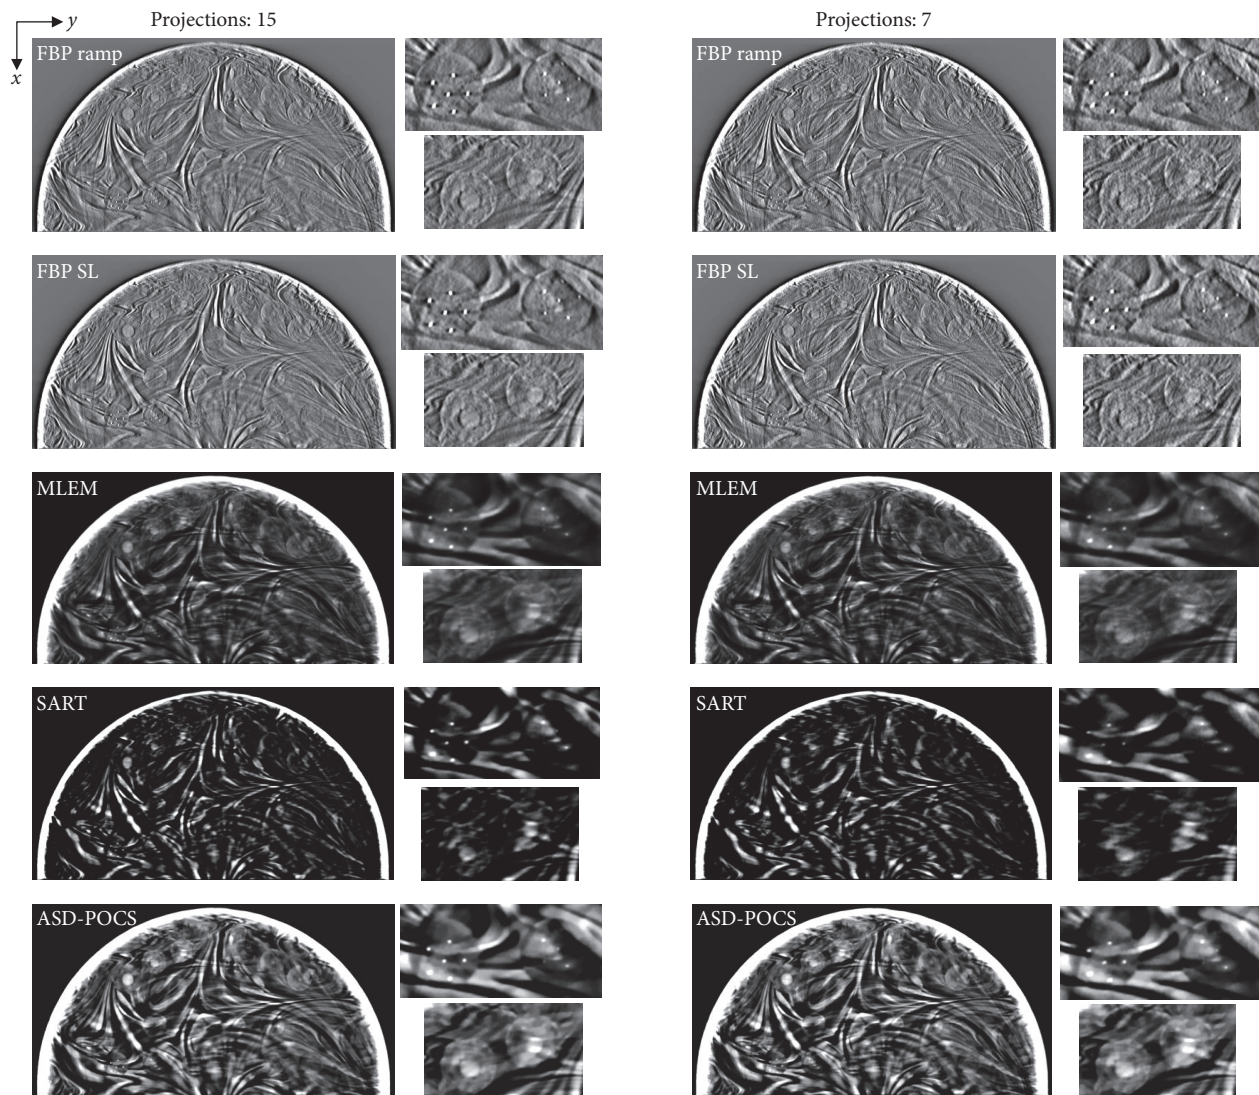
Comparisons between different projection number (normal: 15, half: seven) images obtained using each tomosynthesis reconstruction algorithm in the in-focus plane. The X-ray source was moved horizontally along the image. Zoomed images: microcalcifications, spheroidal masses. For corresponding images, the IR (MLEM, SART, and ASD-POCS) images are displayed at the same window width and level, whereas the FBP images have a larger window widths because the backgrounds are less flattened and the gray levels in larger areas would be out of scale in narrower windows.
